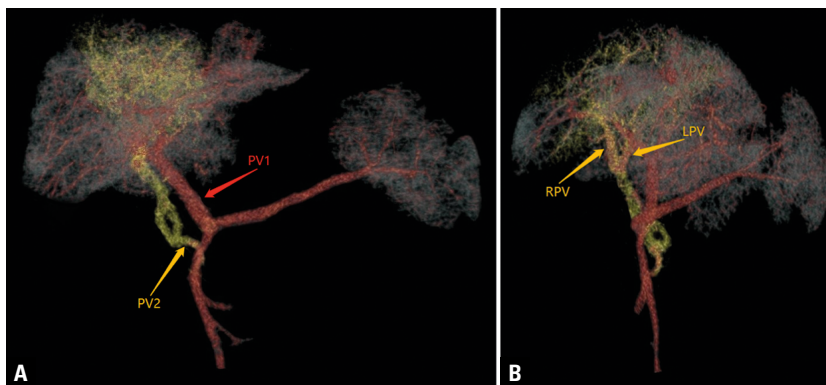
Volume-rendered images of CTA. A. PV1 derived from the junction of SMV and SV. PV2 derived from SMV forming the vein fenestration. B. PV2 dividing into RPV and LPV after entering the liver. CTA — computed tomography angiography; LPV — left portal vein; RPV — right portal vein; SMV — superior mesenteric vein; SV — splenic vein.
